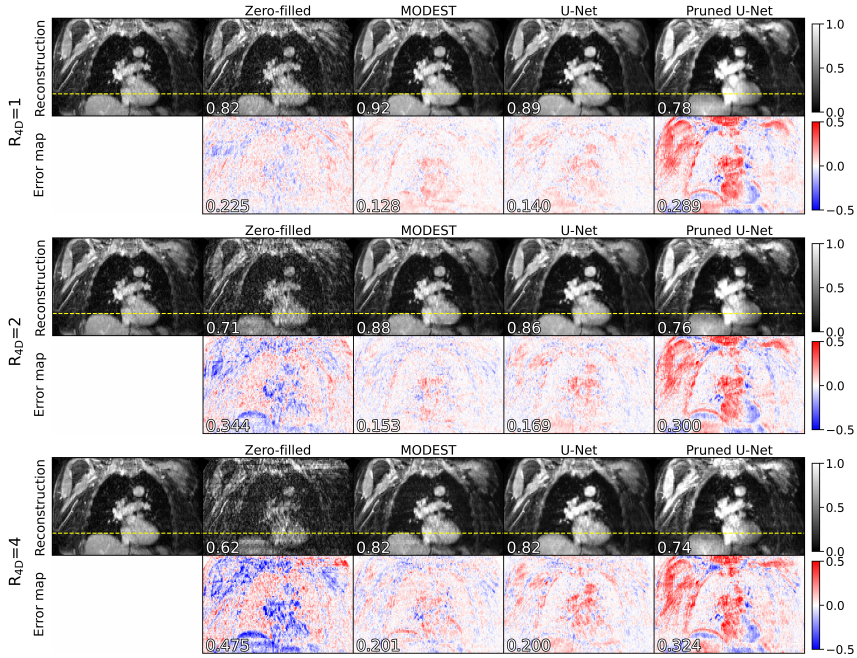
Example reconstructions. 4D-MRI was acquired of a female, 81 years old, affected by adenoma (T2N3M1). Reconstructions of phase-undersampled 4D-MRI inhaling by zero-filling, MODEST, the U-Net, and the parameter-pruned U-Net are shown for several undersampling factors and are compared to the XD-GRASP reconstruction. The top row shows the magnitude reconstructions and the SSIM, while the bottom row shows the NRMSE map and the mean NRMSE value for the 4D reconstruction. In Figure 5.4, a quantitative evaluation for the entire test set is shown.
